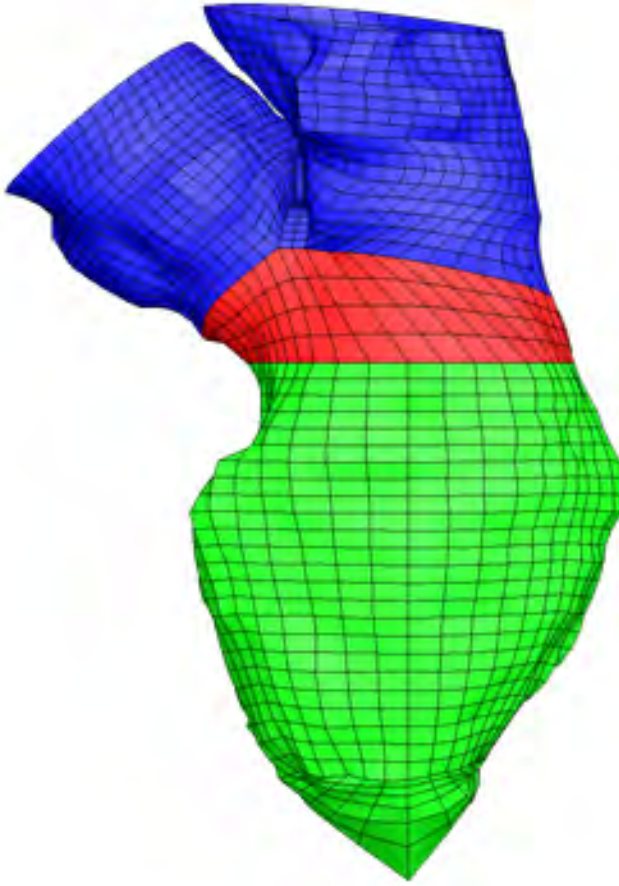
LV divided into three parts: LV sac (in green), Y-junction (in blue), and connection between the two (in red) [4D CT dataset].
